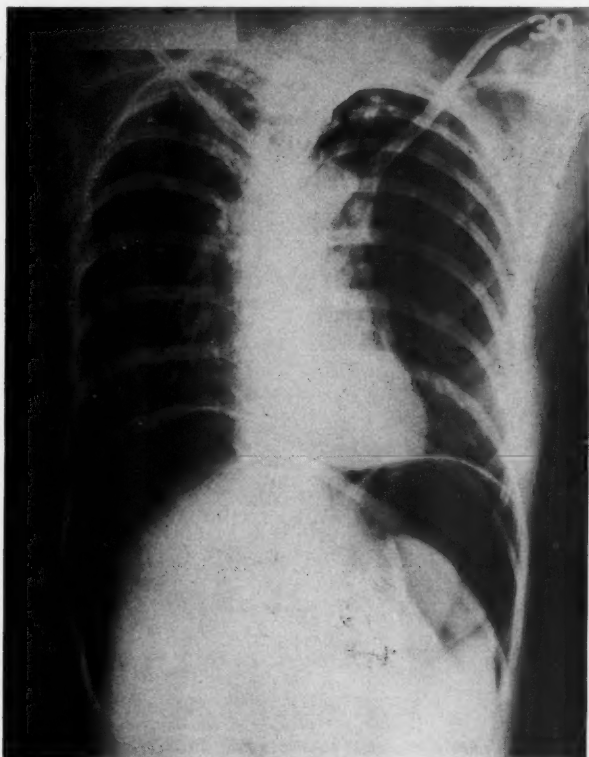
Upright roentgenogram of abdomen and chest, July 30, 1954, showing pneumoperitoneum following air contrast studies.
